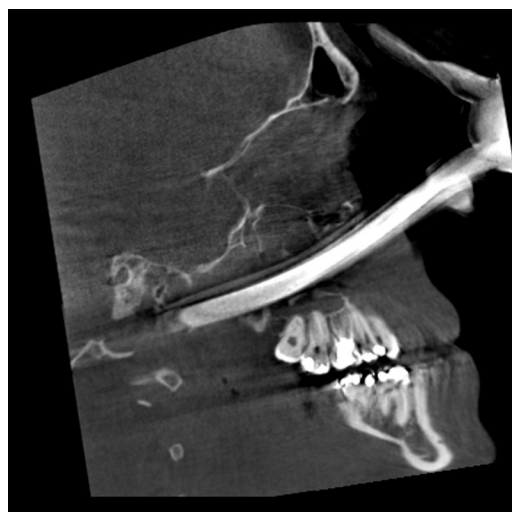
Lateral CT scan of a patient's head revealing a penetrating metallic, radio-opaque pliers handle in the right maxillary sinus and right infratemporal fossa.
